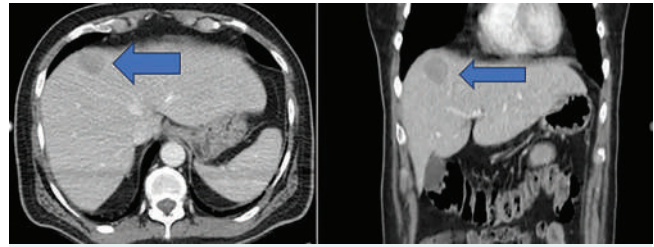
Solitary liver lesion detected on preoperative contrast-enhanced abdominal CT.
